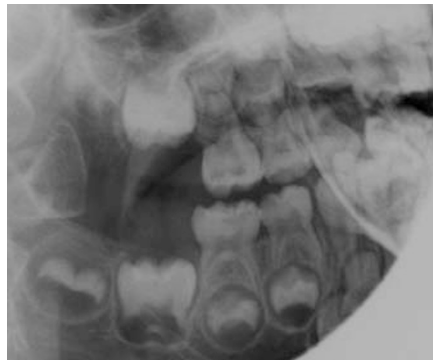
Lateral oblique radiograph of 84. The lesion is limited to the outer half of the dentine
